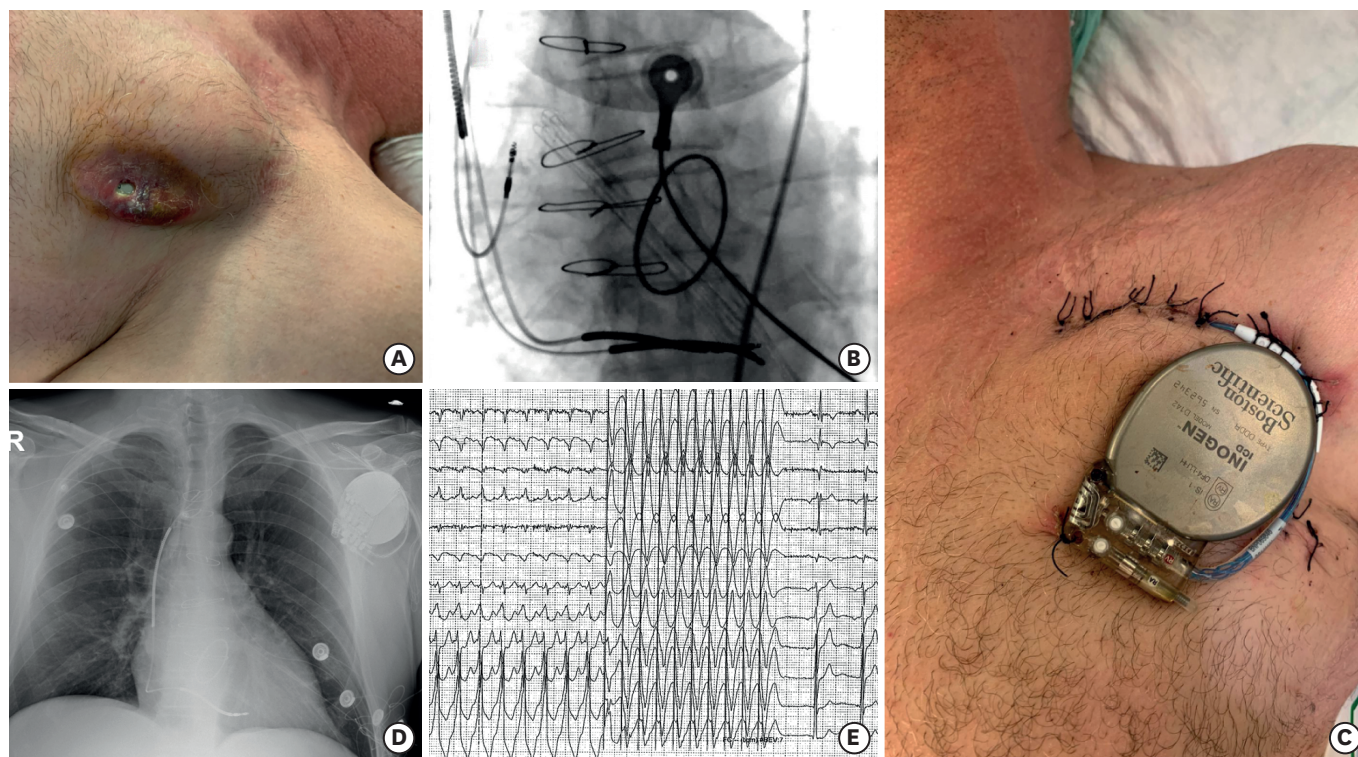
(A) Cardiac implantable electronic device pocket infection. (B) Fluoroscopic image of the implantation of a bridge system with an active-fixation dual-coil lead (Durata™; St. Jude Medical, Saint Paul, MN, USA). (C) Patient's generator (Boston Scientific) disinfected and fixed externally. (D) Post-procedural Radiography. (E) Episode of sustained VT, interrupted by a burst of antitachycardia pacing.
